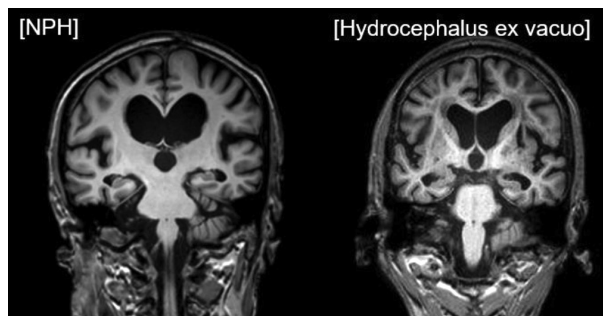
MRI images of the idiopathic normal pressure hydrocephalus and hydrocephalus ex vacuo. The image on the left represents iNPH, showing a small callosal angle (CA), dilatation of the Sylvian fissure, and narrowing of superior parietal sulci. The image on the right represents hydrocephalus ex vacuo with a large CA, no dilatation of the Sylvian fissure, and absence of narrowing of superior parietal sulci. iNPH: idiopathic normal pressure hydrocephalus.
